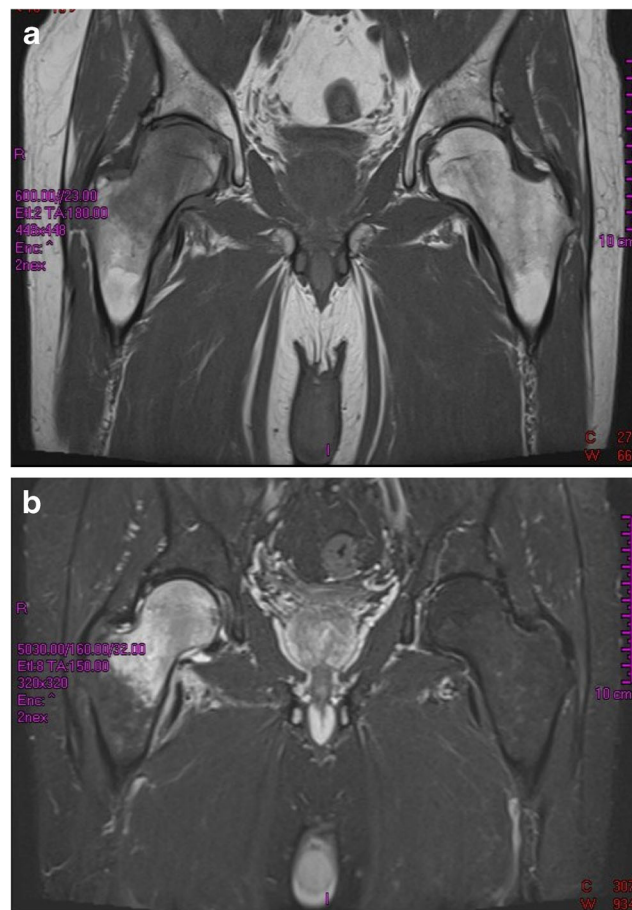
Coronal T1-weighted (a) and T2-weighted (b) MR images of the right hip revealed extensive bone marrow edema in the right femoral head and neck, mild joint effusion without signs of fracture (subchondral, subcapital, or femoral neck). Diffuse pattern of edema with no focal defect, fracture, and subchondral changes is in favor of bone marrow edema or TOH
